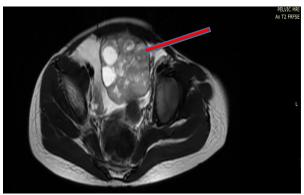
Axial view of Pelvic MRI (T2) showing a round heterogenous mass with multiple focal cystic areas in the left pelvic cavity
